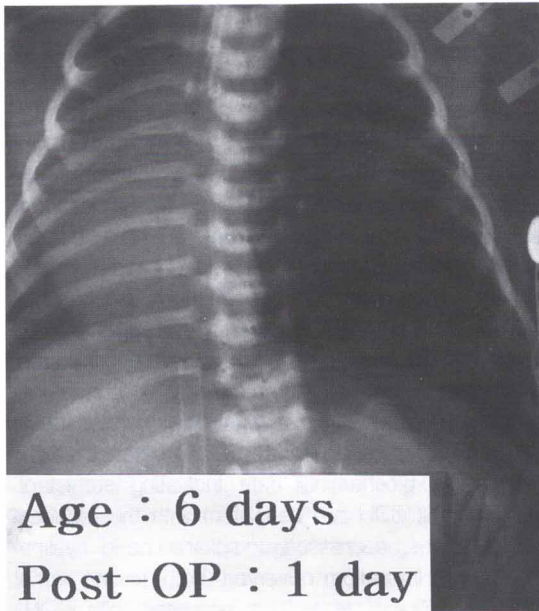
The chest roentgenogram obtained immediately after operation showed pleural effusion and small, hypoplastic and collapsed left lung.
